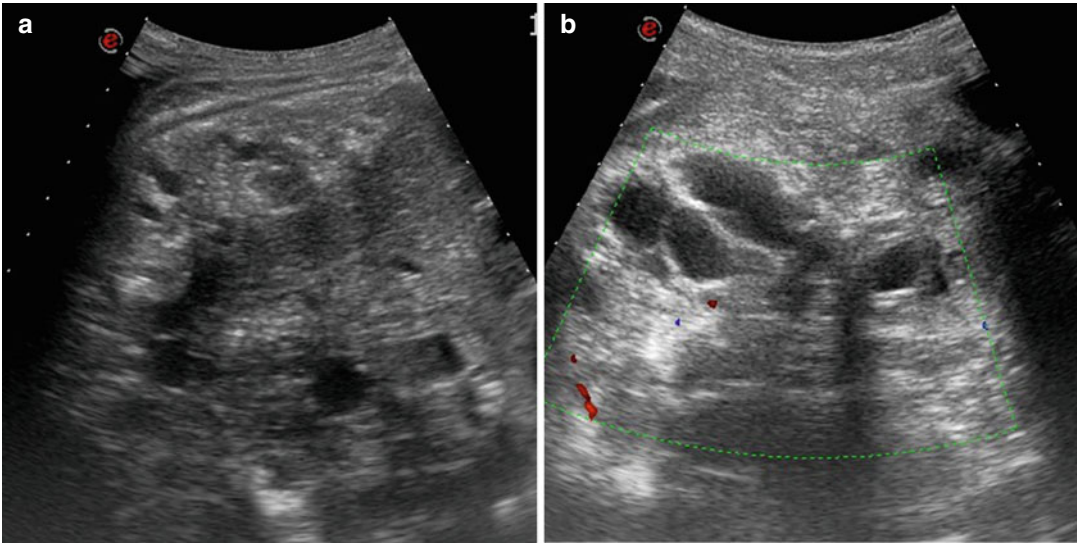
Ovarian immature teratoma. Abdominal ultrasound. (a, b) The complex mass completely fills the pelvic space
